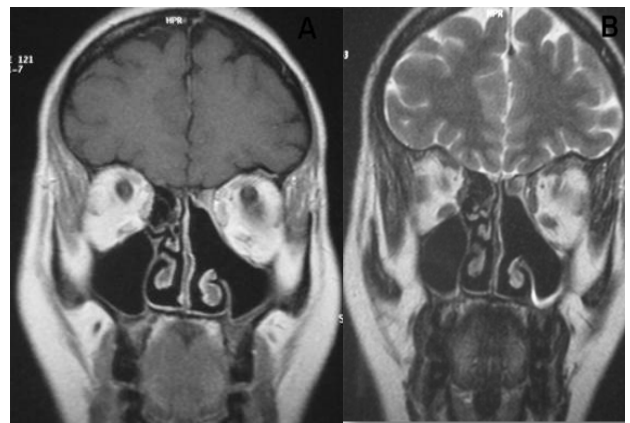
Postoperative MRI in T1 (A) and T2 sequence (B)
